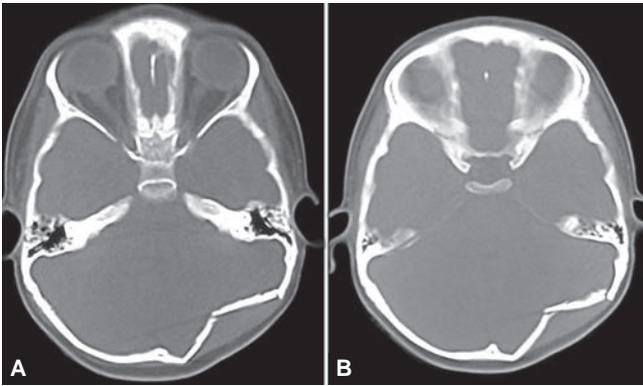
to C: Axial CT sections of brain: showing depressed fracture of occipital bone on left side with inward displacement of the fracture fragments causing mild mass effect over the left cerebellar hemisphere and effacement of fourth ventricle on same side and has a relatively small volume and hence any lesion has the potential to further reduce its volume leading to rise in intracavitary pressure.⁶ Most of the patients
